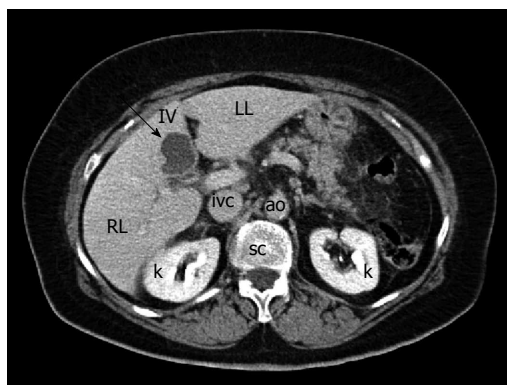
Computed tomography shows the biloma as a hypodense lesion in the IV hepatic segment, characterized by absence of enhancement after administration of intravenous contrast agent (arrow). RL: Right hepatic lobe; LL: Left hepatic lobe; IV: Fourth hepatic segment; k: Kidney; ivc: Inferior vena cava; ao: Aorta; sc: Spinal column.
